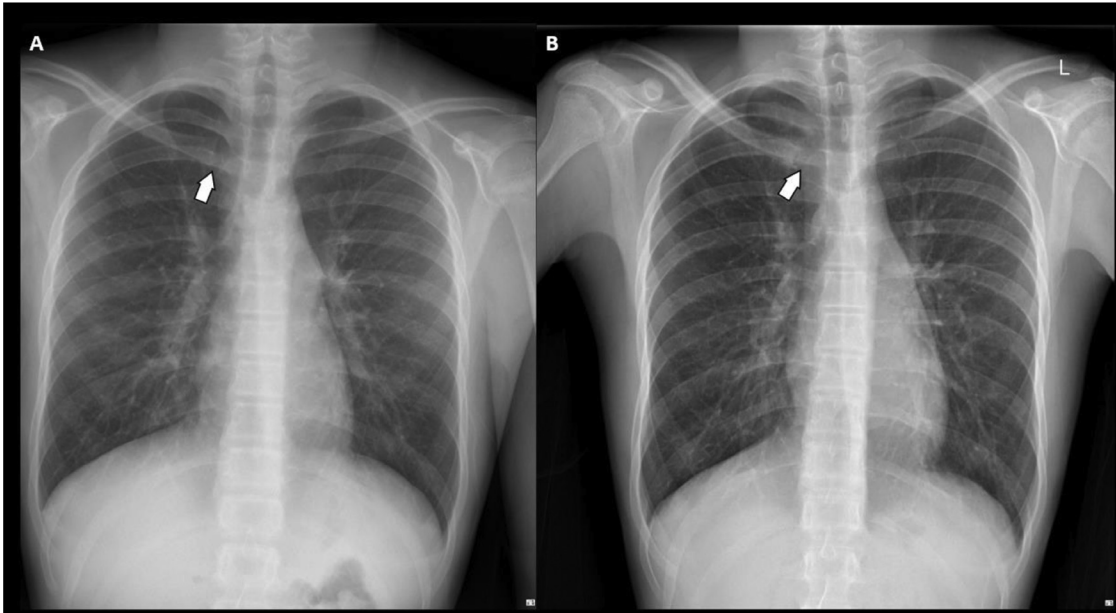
Comparison between chest X-rays taken on the day of patient's presentation (B) and 2 years prior (A), showing subtle irregularity along the right sternoclavicular joint margins compared to the earlier X-ray.
